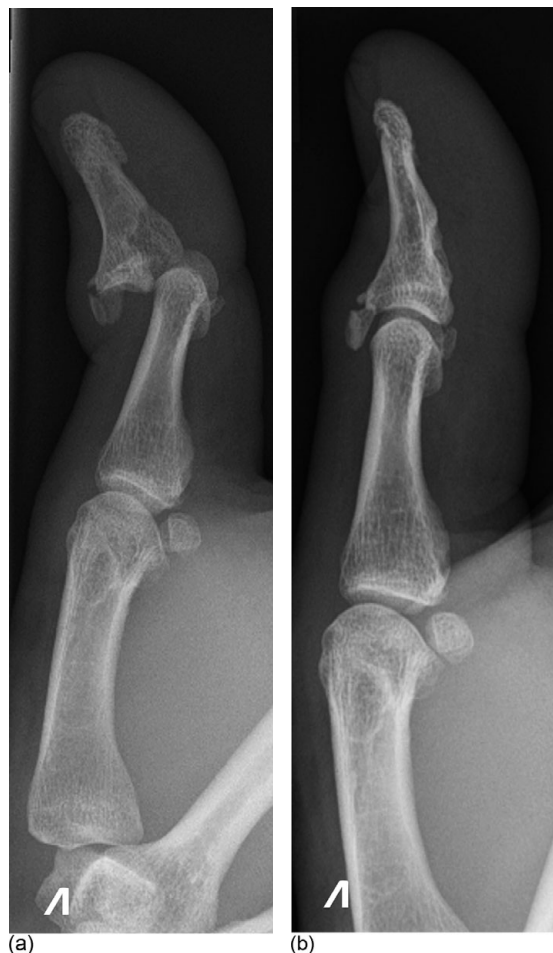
Lateral thumb radiographs (a) pre-reduction and (b) post-reduction
